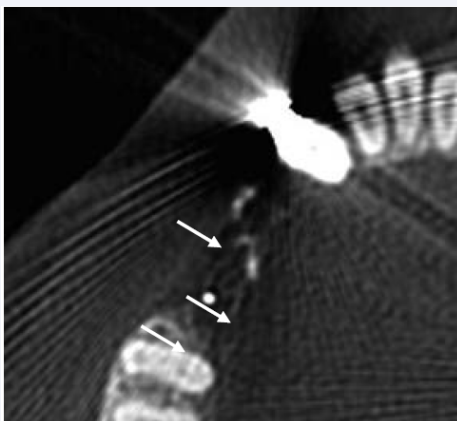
Comparison of X-ray image before and after implants placement
